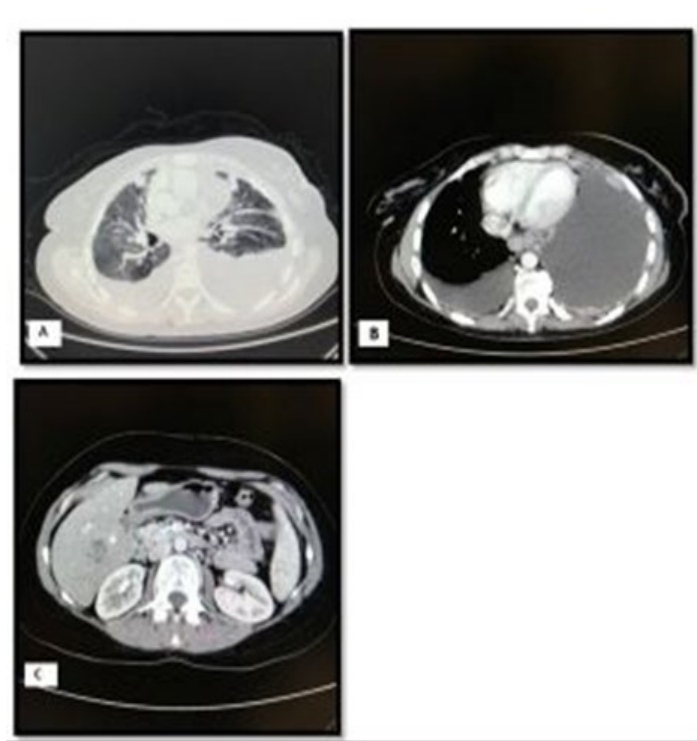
Selected images from the CT examination of a left-sided breast cancer patient with distant metastasis (Stage IV). These axial images through the lower chest and upper abdomen reveal bilateral lung nodules representing lung metastasis (A). Bilateral pleural effusion with nodular pleural thickening is more evident on the left side representing pleural metastasis (B). Heterogeneous enhanced mass in the liver represents liver metastasis (C).
